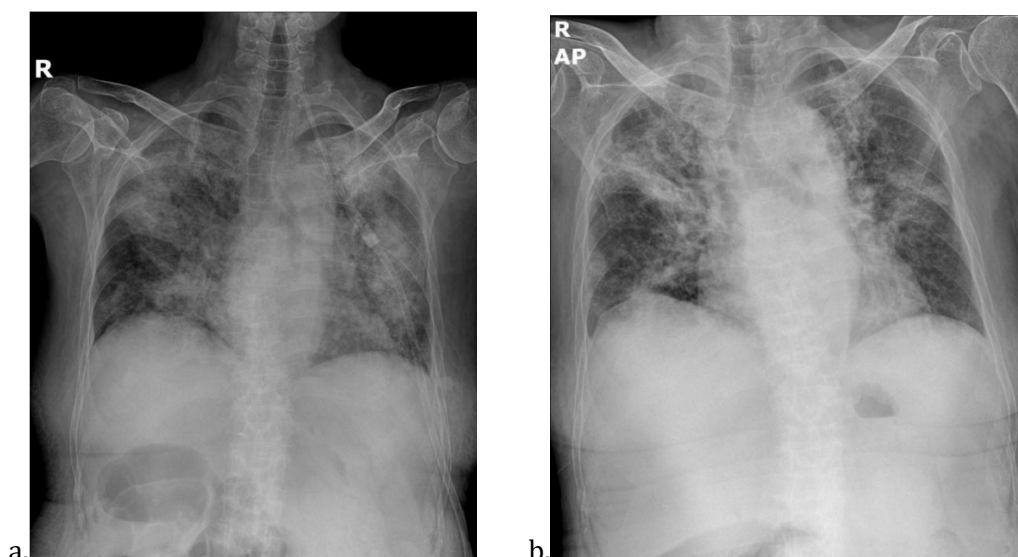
a. Chest X-ray after 10th day of hospitalization; b. Chest X-ray 21st day of hospitalization
